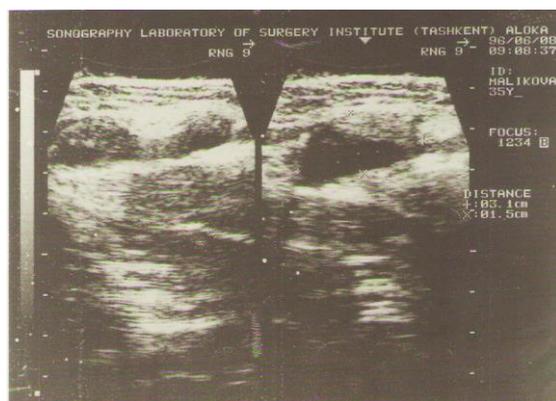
Ultrasound. Traumatic aneurysm of the right brachial artery.
